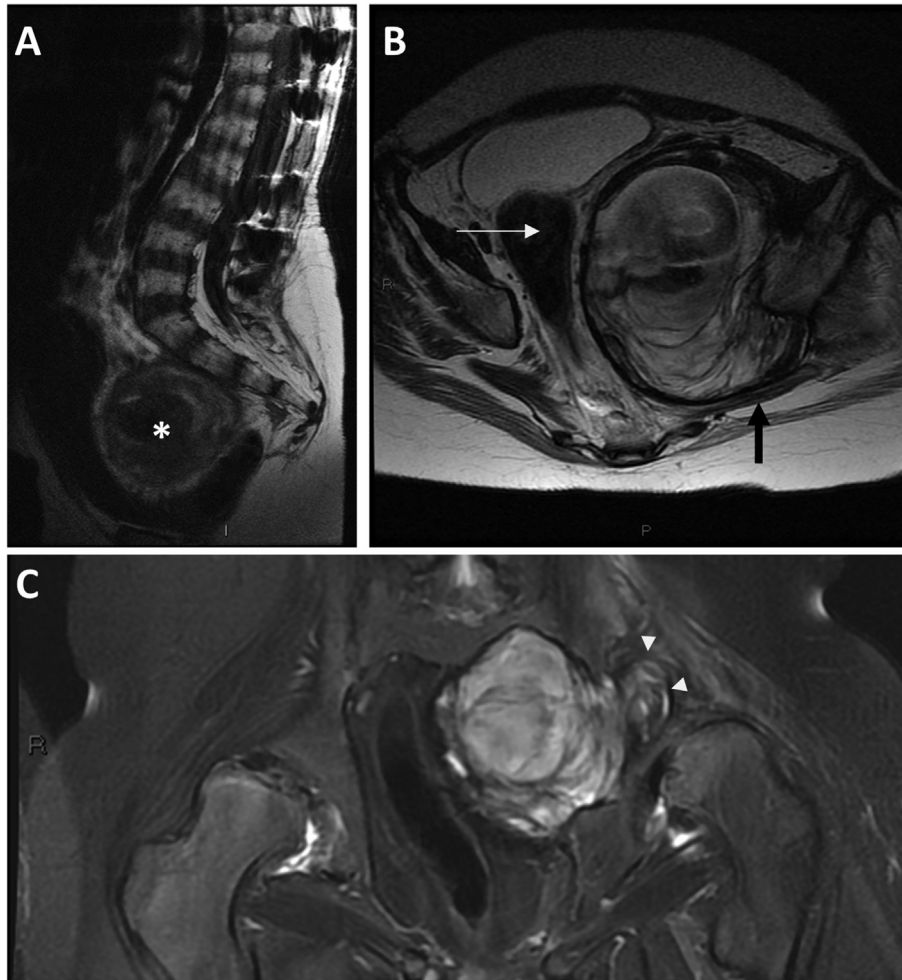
(A) Sagittal section of a T1 weighted lumbar spine MRI showing spinal anomalies related to MPS IVa and lumbar osteosynthesis material related to past surgery. A large rounded heterogeneous lesion is visible (white star). (B–C) Axial and coronal sections with and without fat signal saturation centered on the pelvic hematoma demonstrating its extension to the greater iliac incisure (white arrowheads) and its mass effect on the pelvic structures (horizontal arrow).
